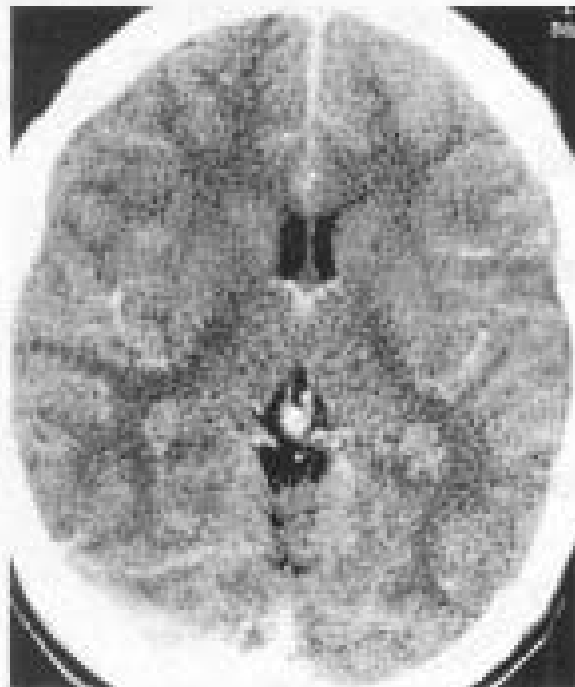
Noncontrast axial head CT scan shows an empty delta sign at the confluence of the superior sagittal sinus and the right transverse sinus.
